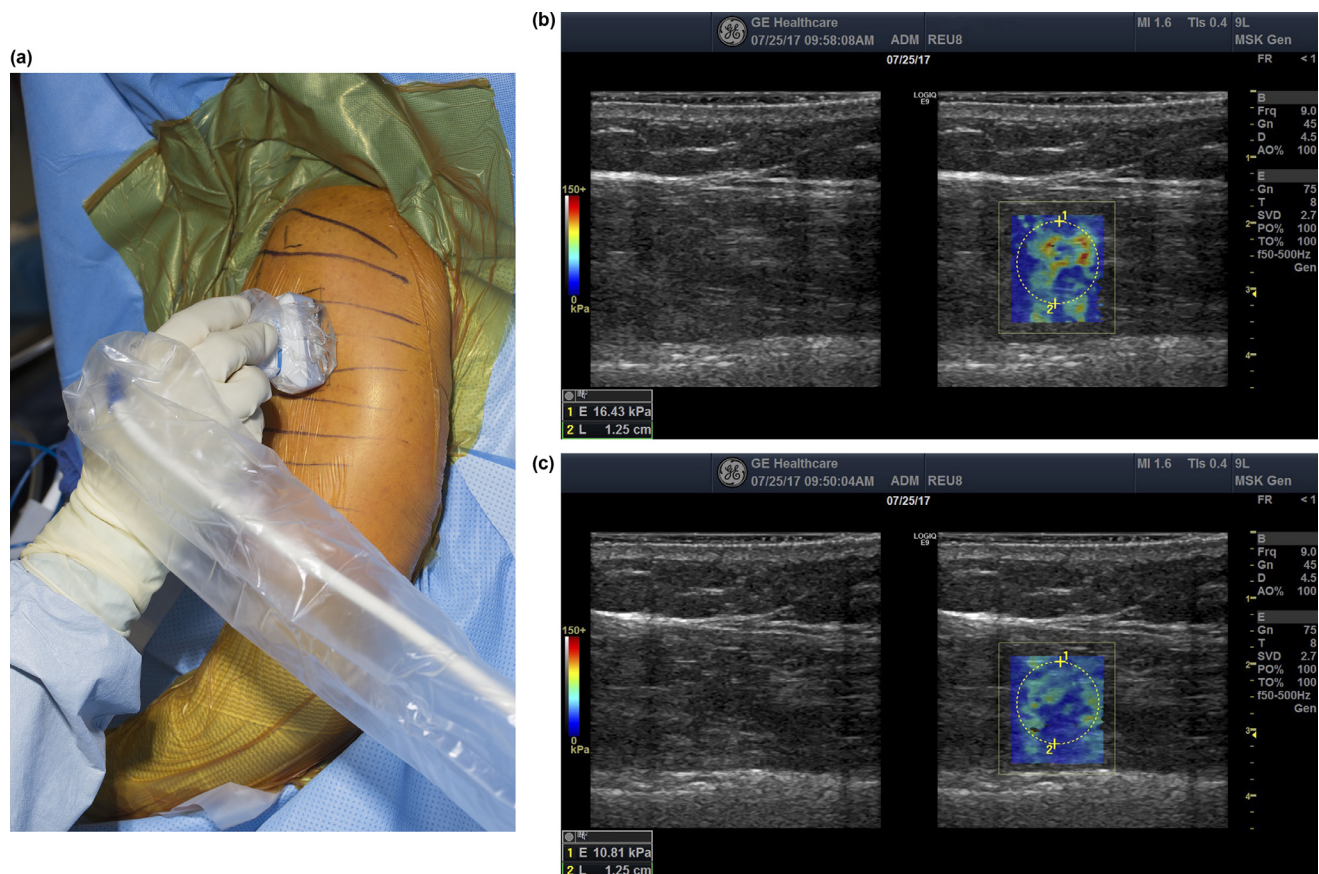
Intraoperative measurements of deltoid stiffness using shear wave elastography. (a) Ultrasound transducer over the region of interest. (b) Captured measurement before component implantation. (c) Captured measurement after component implantation.
